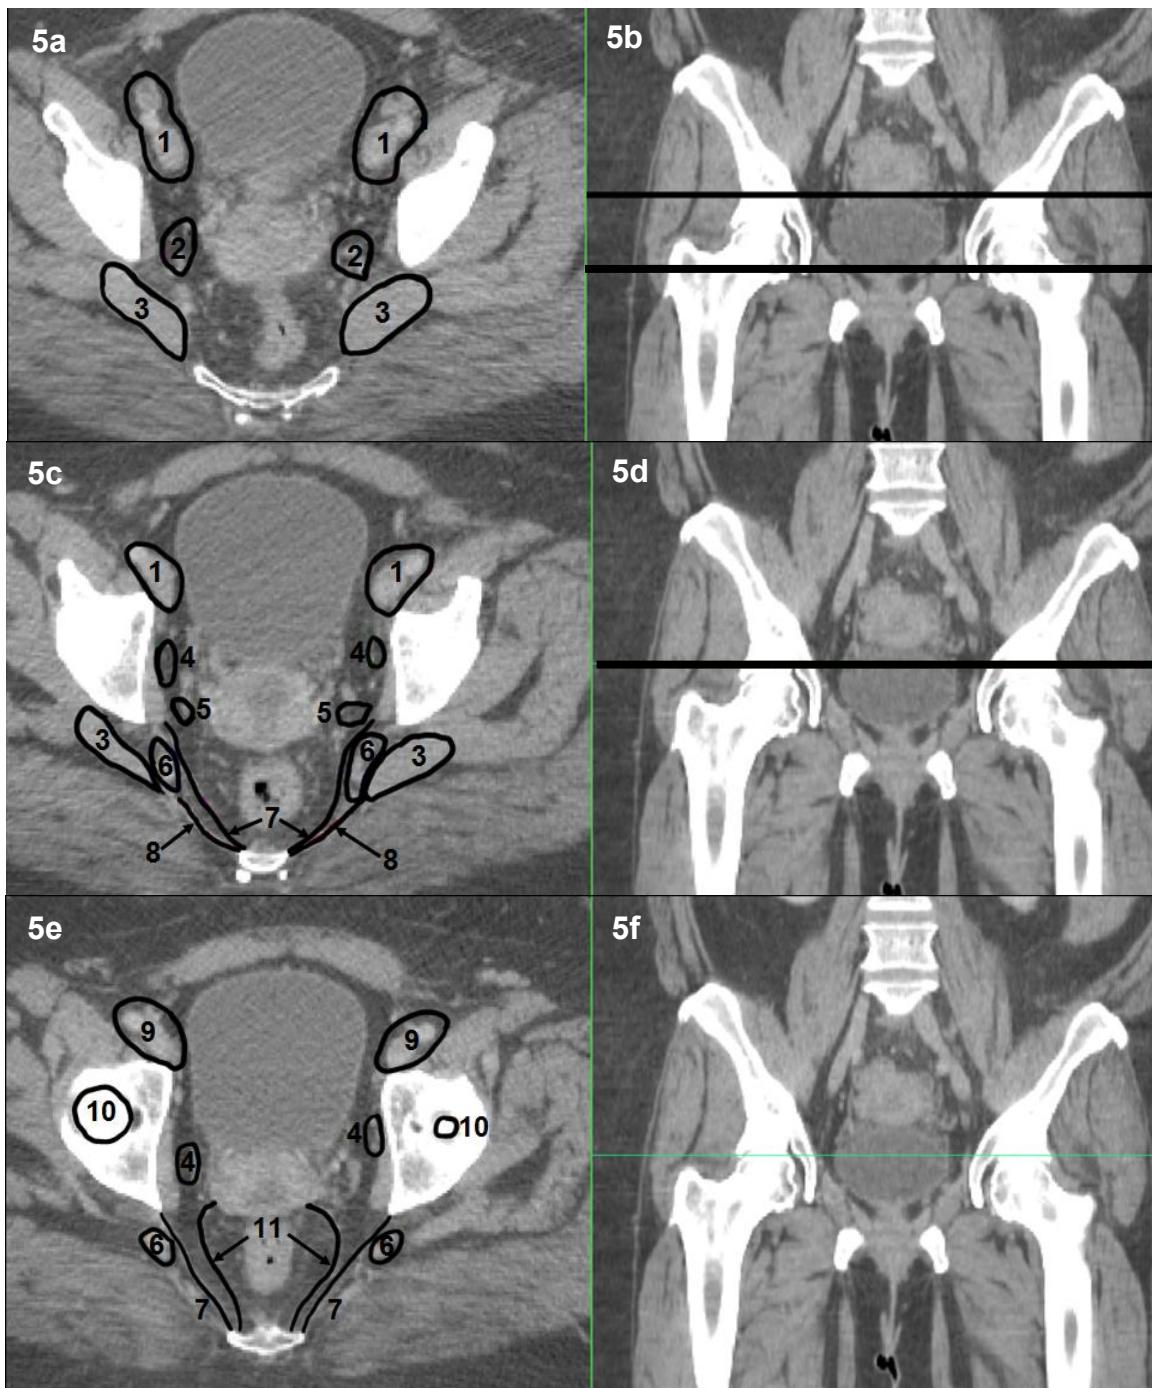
Axial CT images (a,c,e) with line on coronal showing corresponding position (b, d, f, respectively). Anatomical areas: 1=external iliac vessels; 2=junction of gluteal and internal iliac vessels; 3=piriformis muscle; 4=obturator vessels/infra-iliac region; 5=internal iliac vessels; 6=gluteal vessels; 7=sacrospinous ligament; 8=sacrotuberous ligament; 9=inguinal vessels; 10=femoral head; 11=uterosacral ligaments
